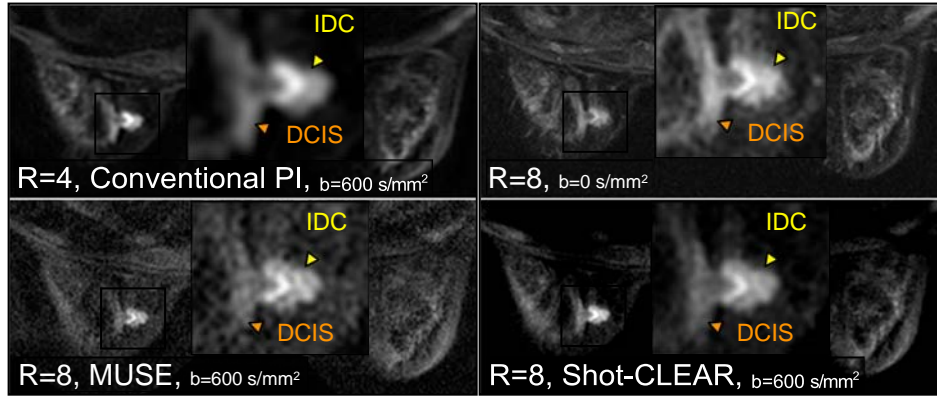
Conventional parallel imaging DWI (256x192) vs multishot DWI methods (384x384) in a patient with DCIS and IDC. In both cases, R is the effective ky acceleration. Shot-CLEAR offers much sharper tumor depiction than conventional DWI, and better SNR than MUSE.
